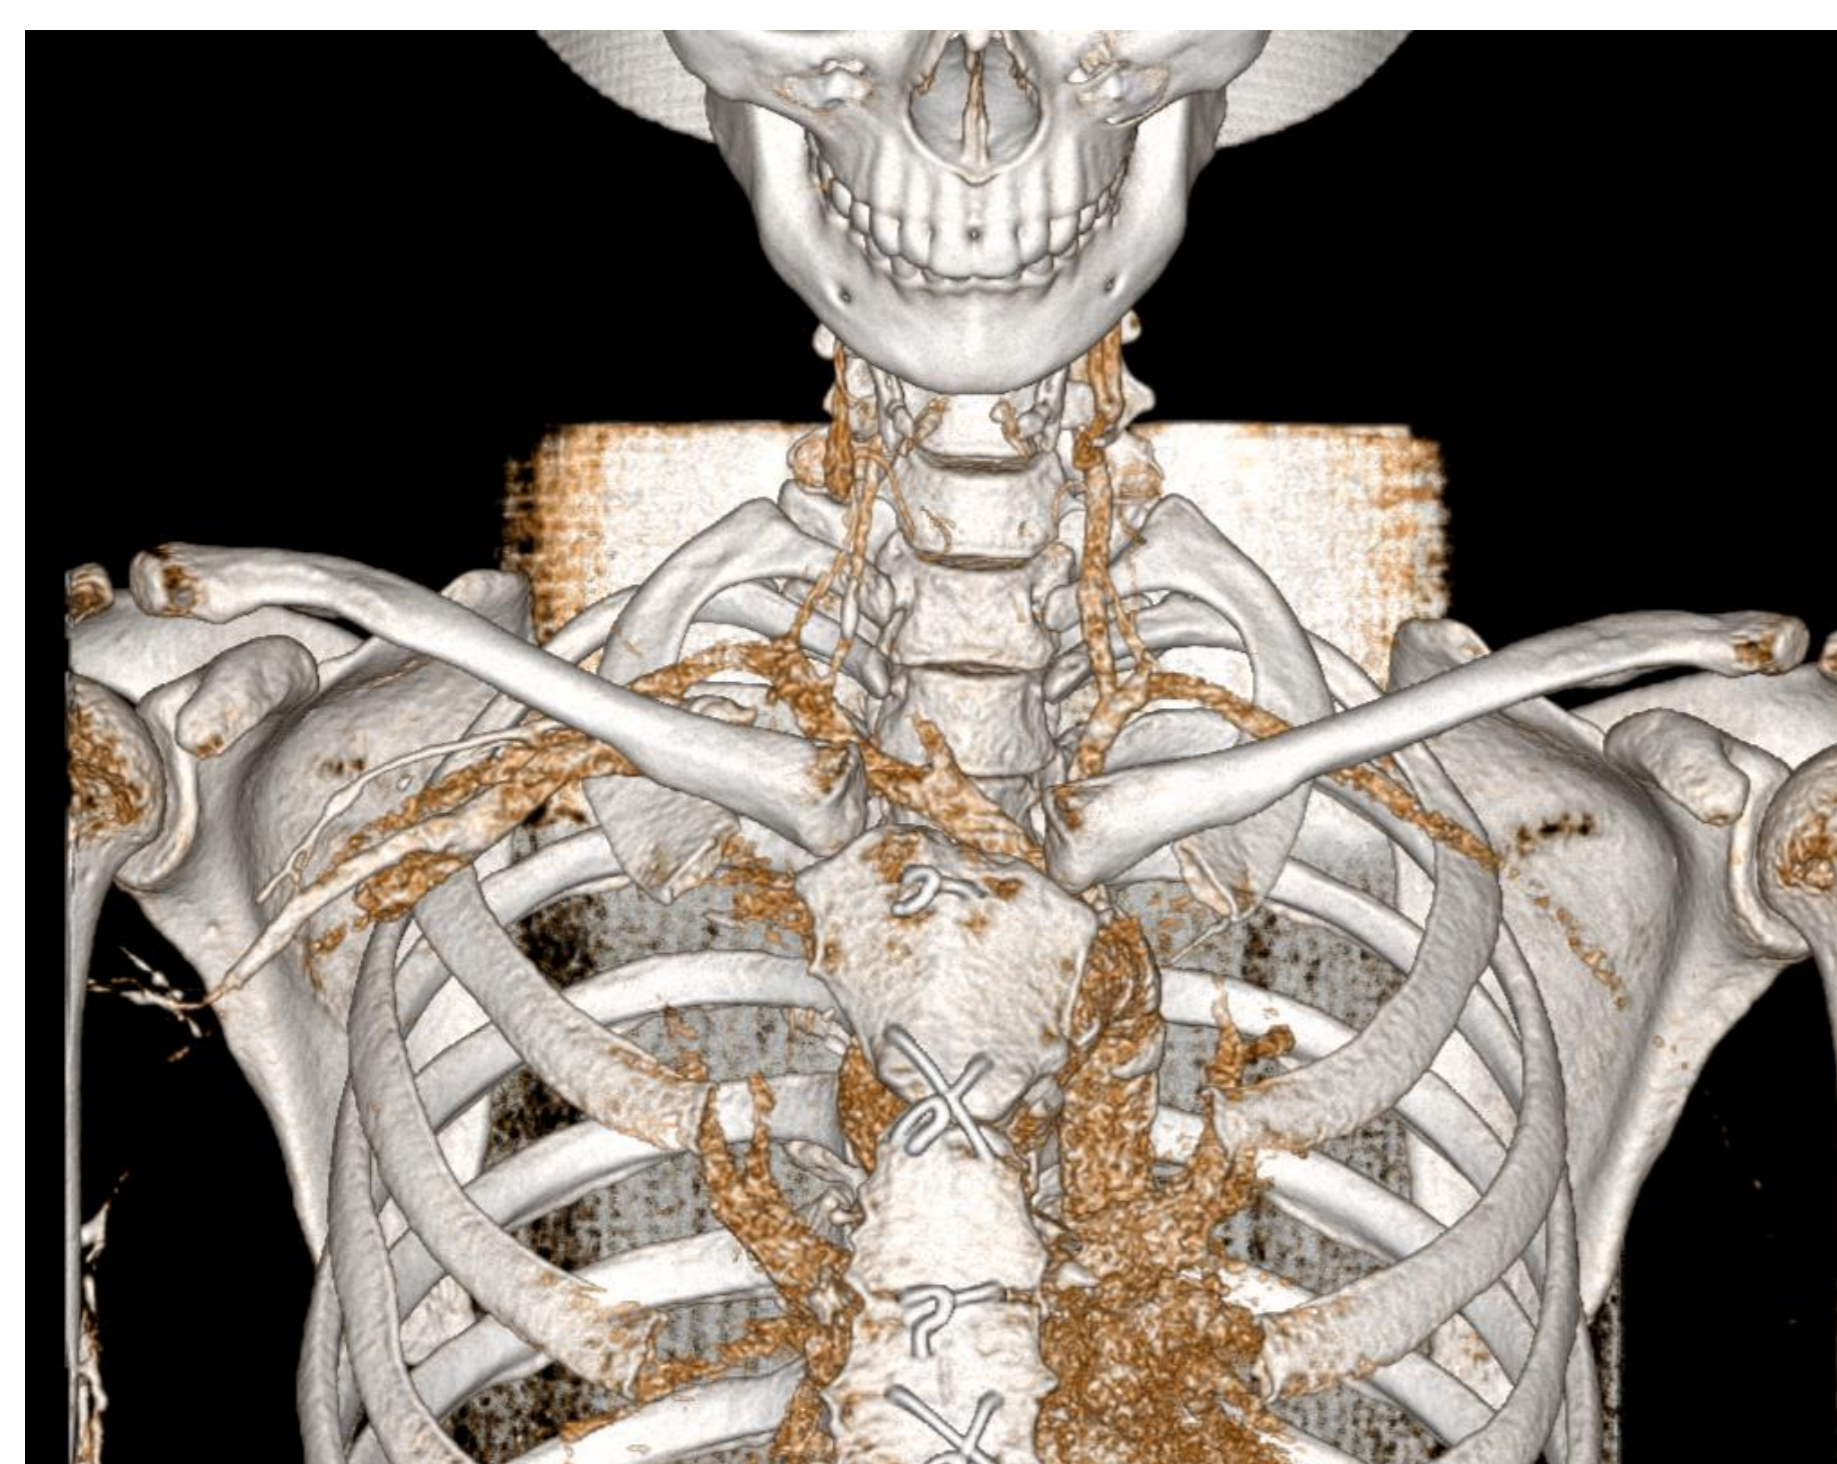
A 3D reconstruction of the patient's CTA scan.
